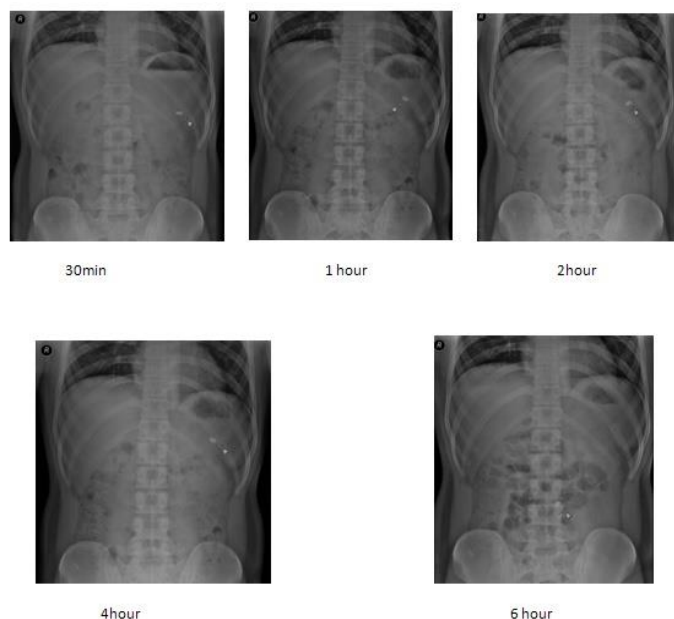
Radiographic Images of Tables at 0.5, 1, 2, 4, 6 hours respectively
